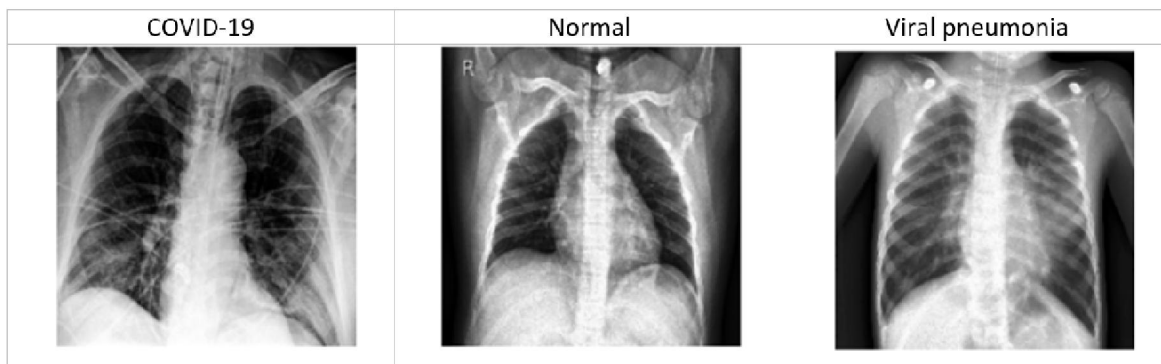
Example of chest X-ray images.
